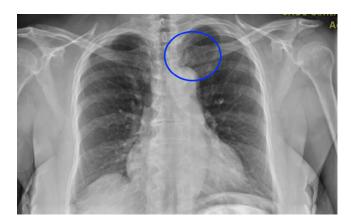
Anteroposterior Chest X-ray displaying a retained portion of guidewire in the left chest.
